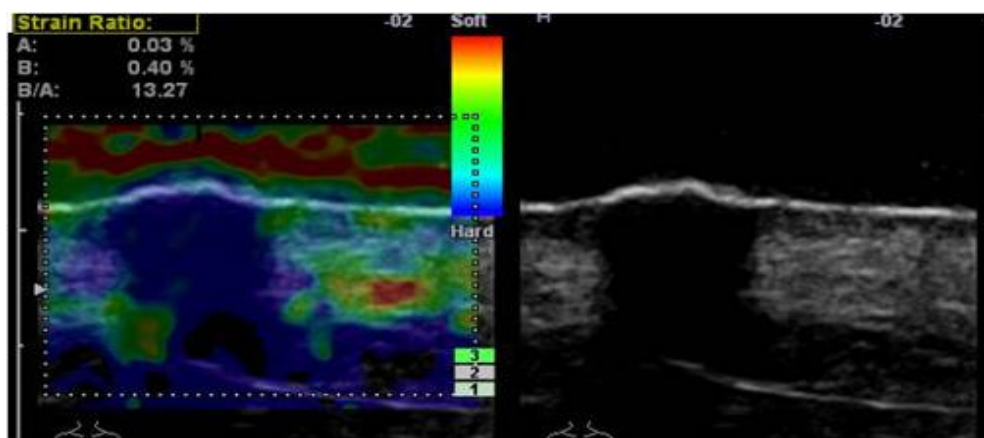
An elastogram (left) and ultrasound (right) showing squamous cell carcinoma of the skin (Harland et al., 2003).
